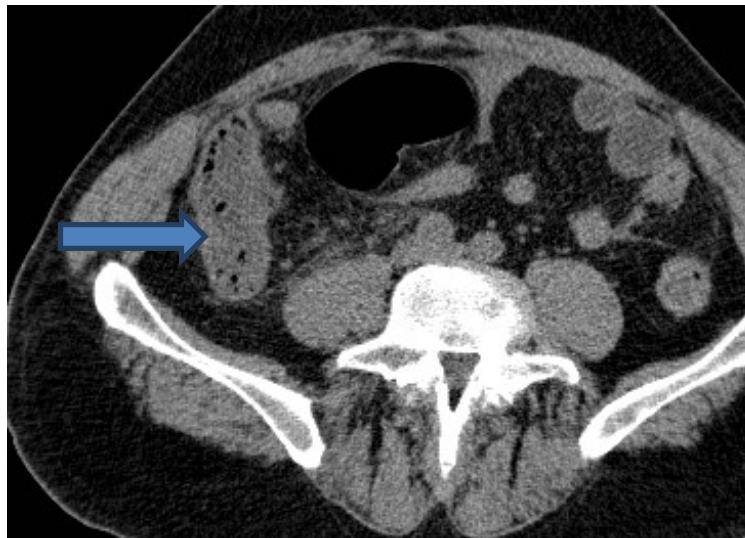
Abdominal CT with contrast enhancement. The arrow points to an enlarged and thickened appendix with suspected perforation. There is some fluid around the appendix
